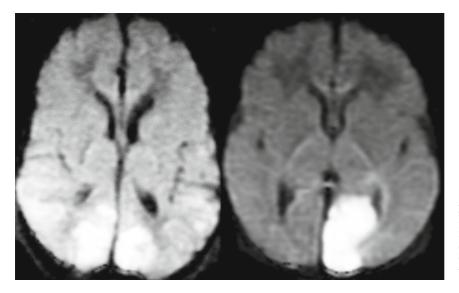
DW axial MRI in a term infant with profound hypoglycemia and seizures: focal bilateral occipital subcortical cell injury may mimick posterior cerebral artery (PCA) stroke (compare with DWI on the right of infant with tip of the basilar artery stroke leading to cerebellar infarction and left PCA pial stroke)
